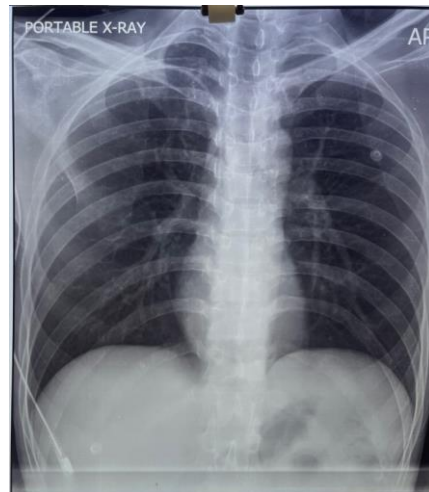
X-Ray plate of a patient
